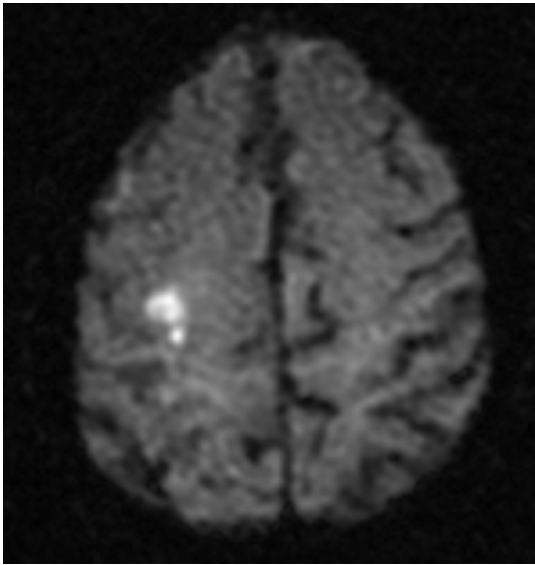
Small cortical lesion on DWI.
